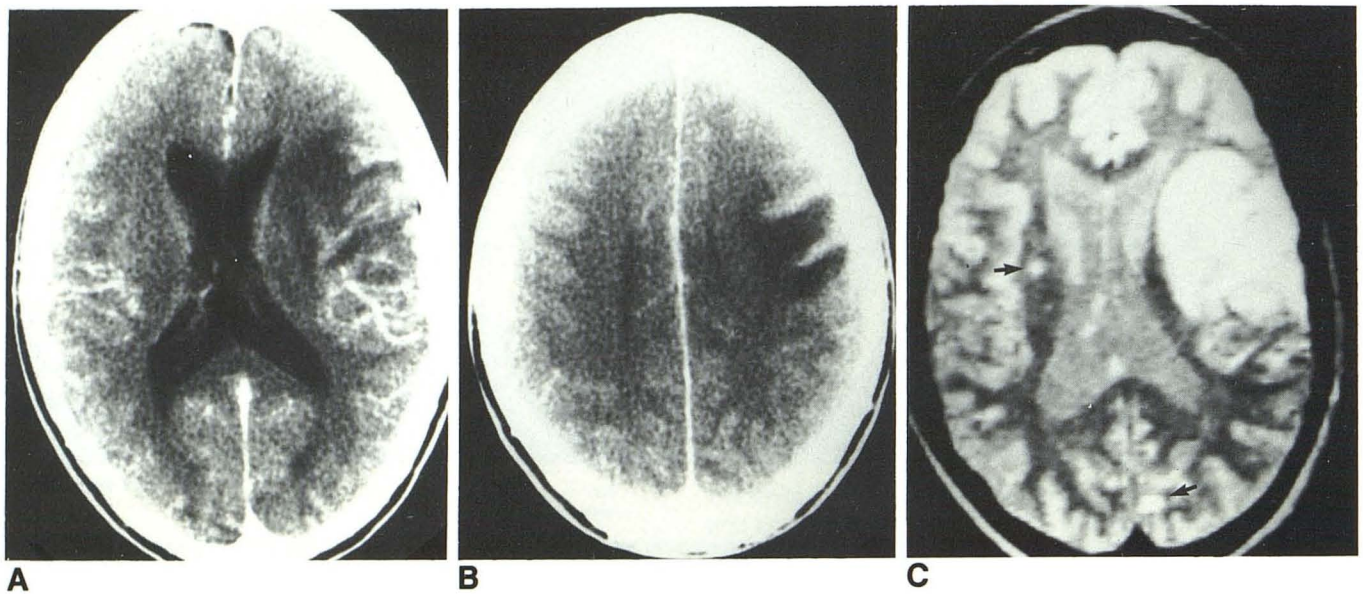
Atypical toxoplasmosis. A and B, CT scans showing left parietal edema with gyral enhancement and compression of left lateral ventricle. C, MRI scan obtained with spin-echo sequence (TR = 2000 msec, TE = 56 msec) on same day shows additional lesions in right corona radiata and in left occipital lobe (arrows).
